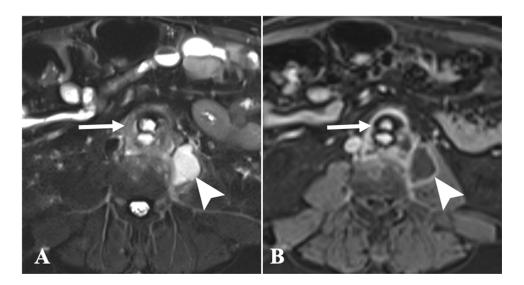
Abdomino-pelvic MRI. T2-weighted MR image (A) revealed marked thickening of the periaortic tissues (white arrow) and confirmed the presence of an intra-muscular liquid collection of left psoas (arrowhead). T1-weighted fat-saturated contrast-enhanced MR image (B) revealed marked enhancement of the periaortic tissues (white arrow), a finding that also supports the presence of significant inflammatory / infectious periaortic changes. Peripheral enhancement (arrowhead) of the psoas collection helped to confirm that it corresponded to an intra-muscular abscess.
